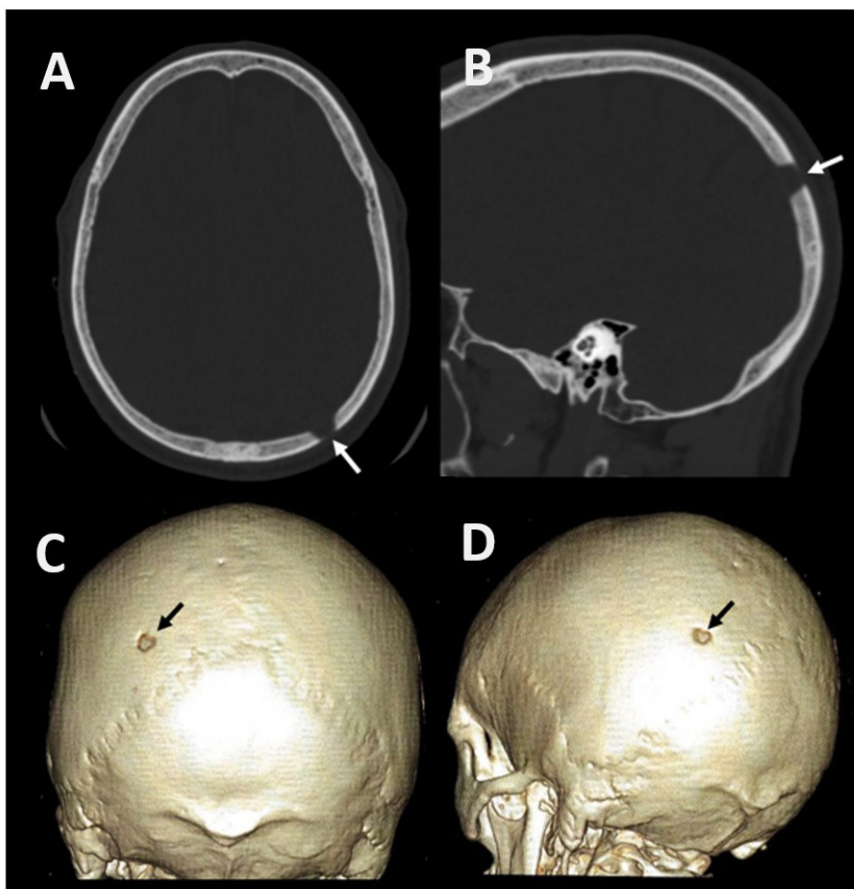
Computed tomography. It can be seen a lytic lesion at the left parietal level with involvement of both cortical (arrows). (A) and (B) images in the axial and sagittal planes, respectively, with bone density window; (C) and (D) 3D reconstructions in volume rendering, back views and side poster mode respectively.
